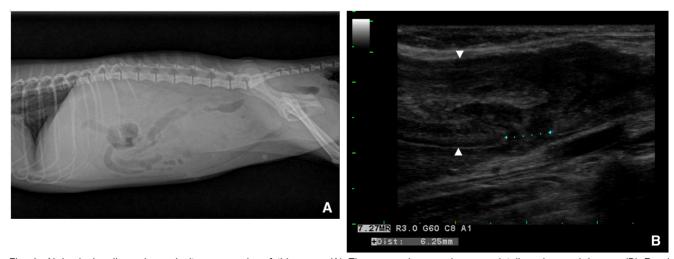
Abdominal radiography and ultrasonography of this case. (A) There was decreased serosa detail on lower abdomen. (B) Focal hypoechoic defect with loss of layering in uterine horn wall was verified (white arrow heads-uterine border).
